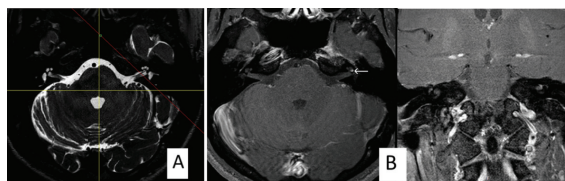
MPR planes of HR-T2W for MRI IAC (A) compared with coronal and axial Gd-T1W (B).
